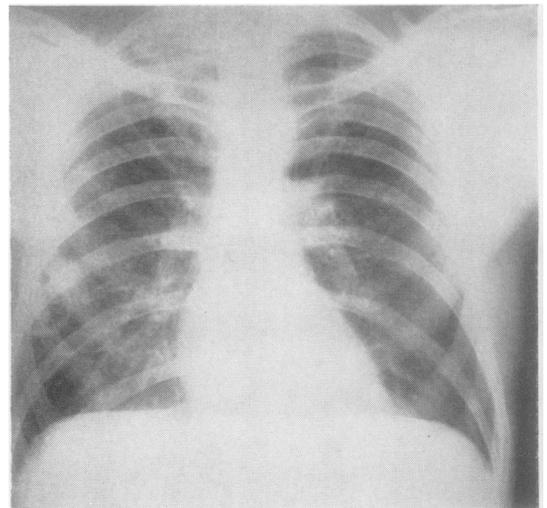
Chest radiograph of April, 1959, showing unusual cavitated lesions in the right lung. No features typical of asbestosis are present.
